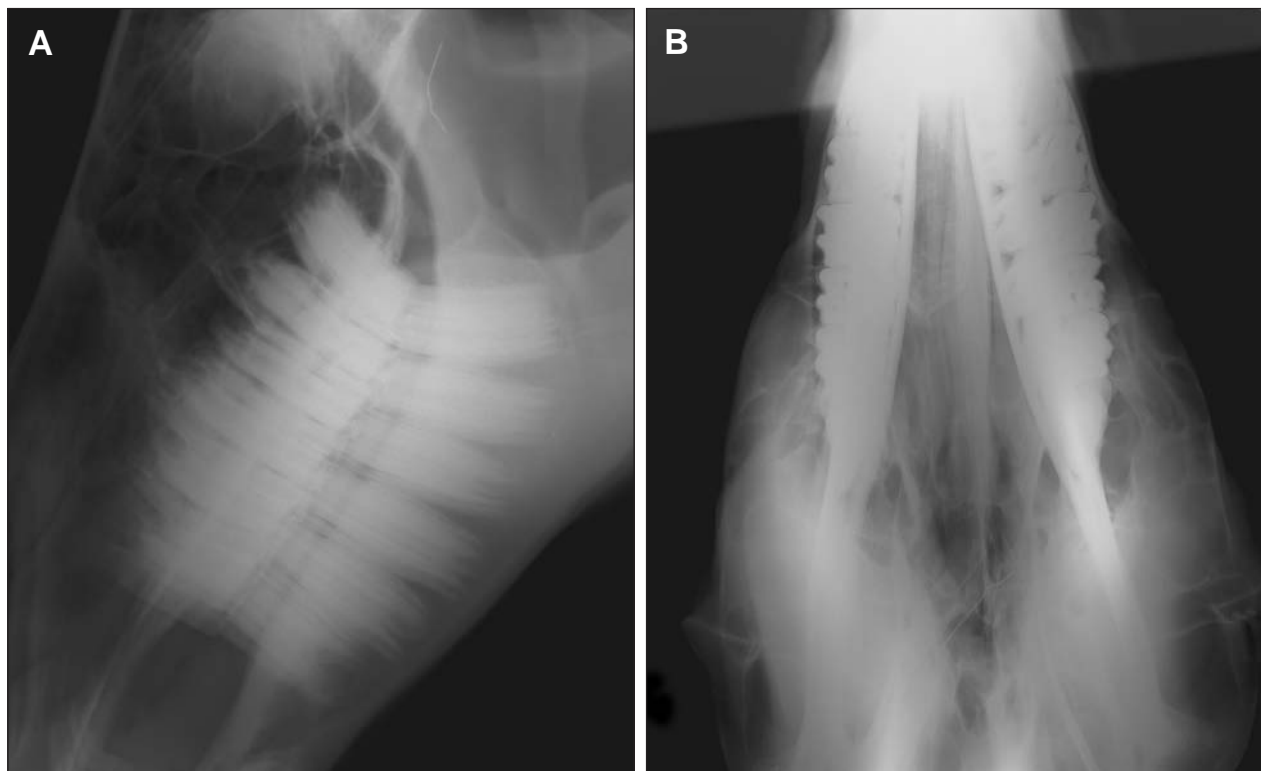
Lateral (A) and dorsoventral (B) radiographic views of the skull of a 10-year-old Hanoverian gelding evaluated for chronic bilateral nasal discharge of unknown duration.
